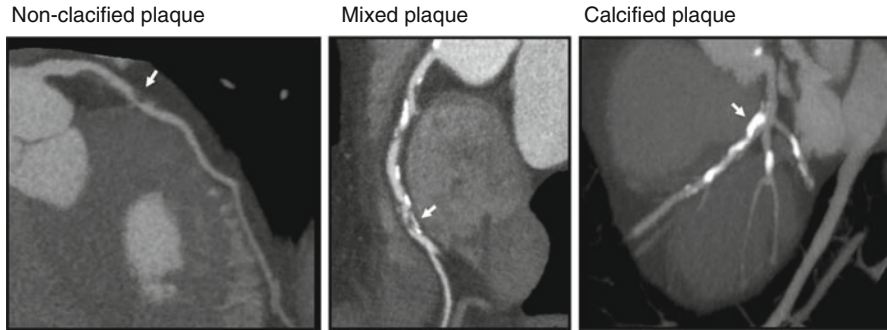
Computed tomography angiography. Plaque composition assessed with CTA. Curved multi-planar reconstructions showing three distinct plaque characteristics observed on CTA with noncalcified plaque (*arrow, left panel*), mixed plaque (*arrow, middle panel*), and calcified plaque (*arrow, right panel*) (Used with kind permission of Springer Science + Business Media from van Werkhoven et al. [8])
